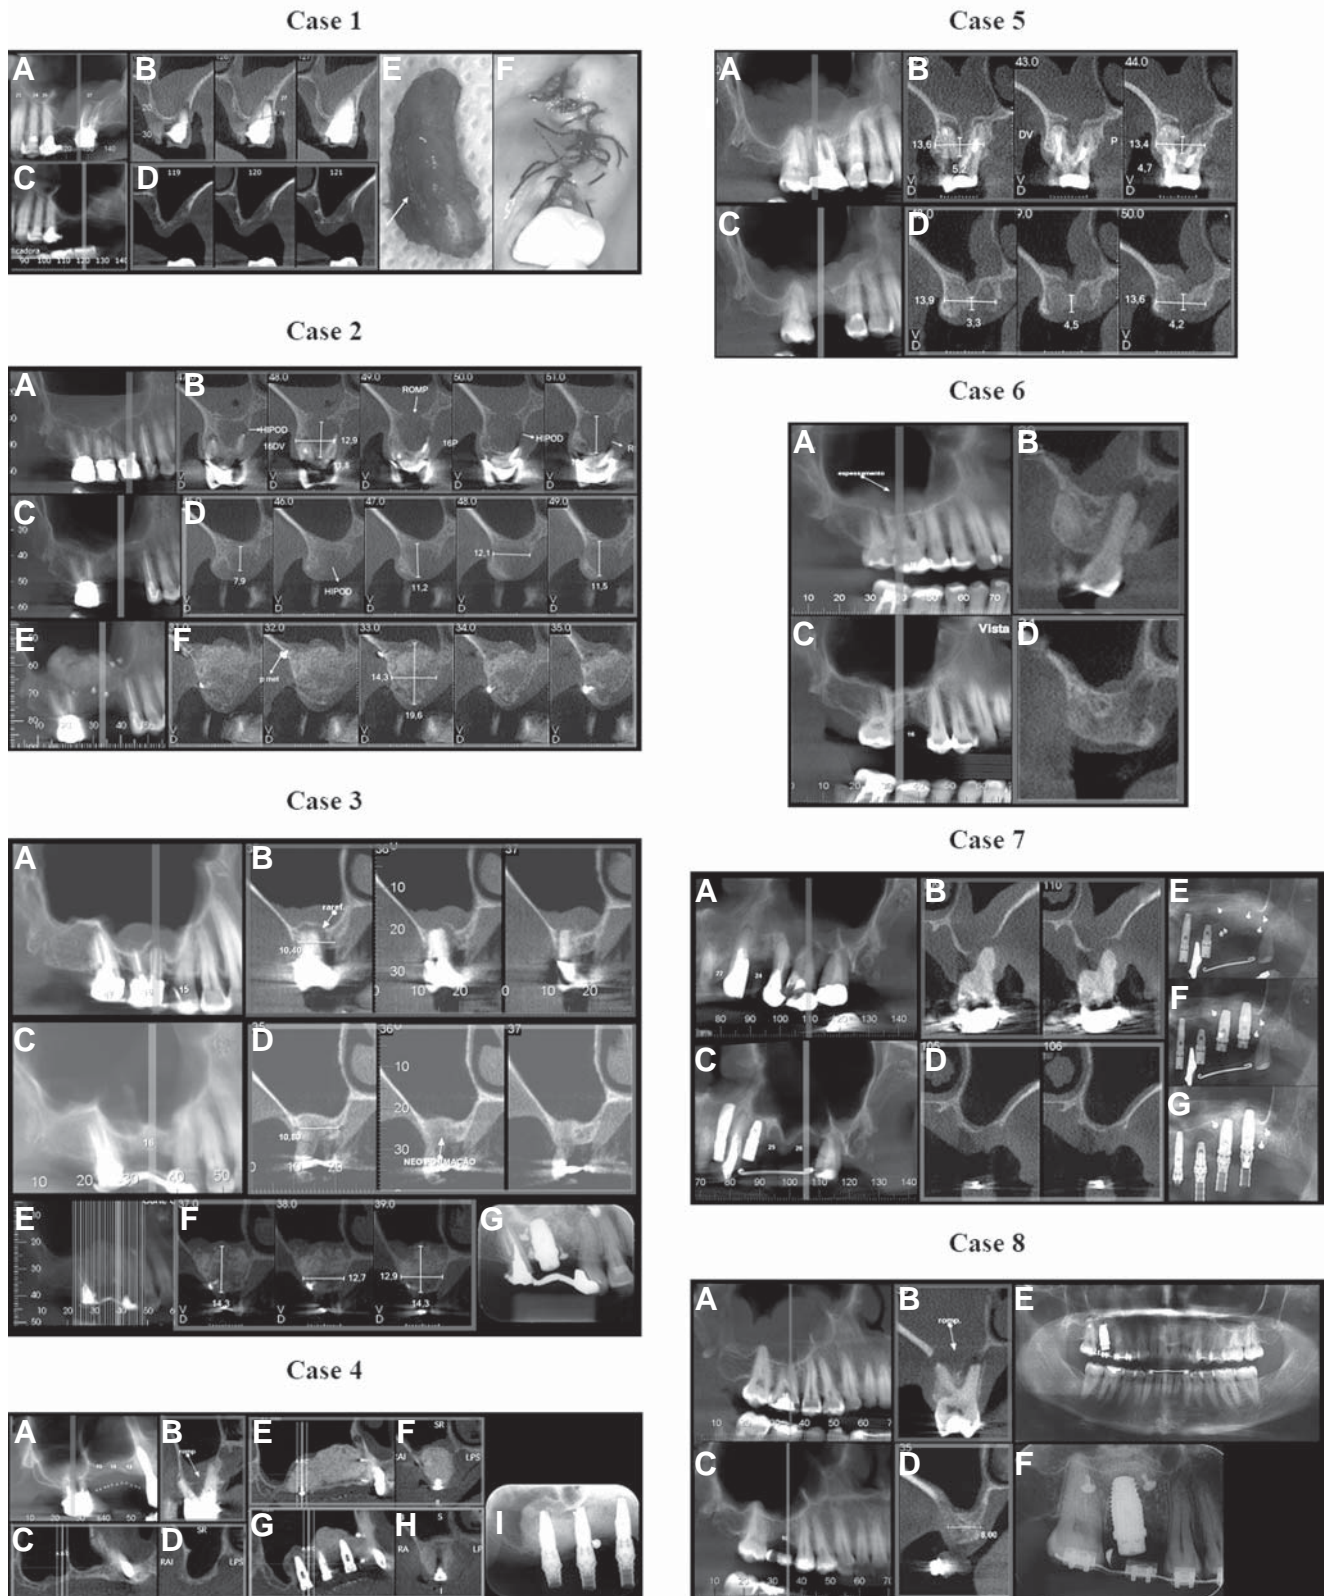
Representative images of this case report. In all the cases, the maxillary rhinosinusitis had the tooth infections as the etiological factor as determinate by clinical exams and CBCT (A-B). All the cases presented clinical resolution of the maxillary rhinosinusitis after the dental extraction (C-D). In some cases, the sinus lift procedure was performed in order to placed the dental implants (Cases 2-4, 7, E-F). Then, the dental implants were placed with no complications (Cases 3-4, 7-8, F-I).
